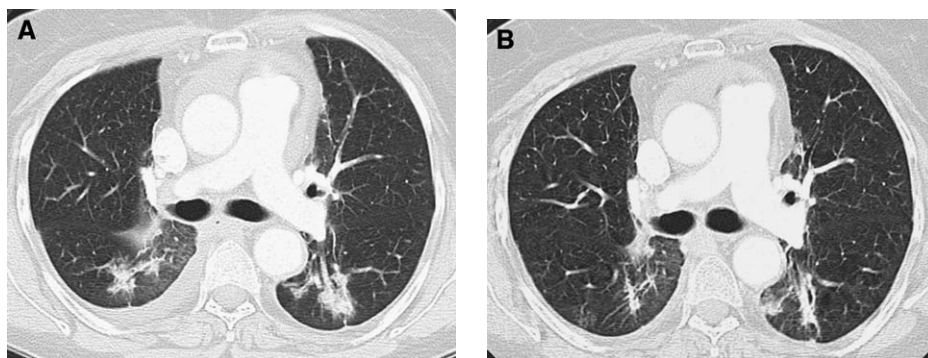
Surveillance by CT of a 57-year-old woman who underwent radiation therapy for a right upper lobe bronchoalveolar cell carcinoma with metastatic mediastinal adenopathy. (A) Axial image 4 months after completion of radiation therapy demonstrates ground glass opacities with a nodular component that is consistent with radiation pneumonitis. (B) Axial image 12 months after completion of radiation therapy shows organization of the ground glass opacities and nodules into fibrosis, indicated by volume loss, bronchiectasis, and consolidation.
